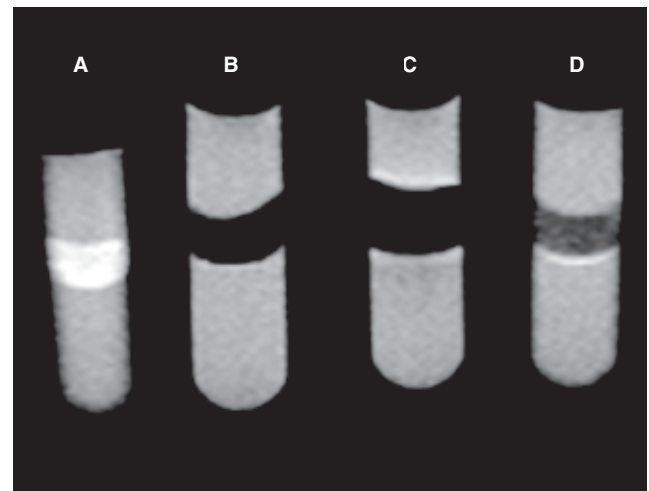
T2-weighted images of USPIO natural killer labeled cells and natural killer cells. A) Unlabelled natural killer cells. B) Ferumoxides Pro-NK-labeled cells. C) Ferumoxides PLL-NK-labeled cells. D) NK-ferumoxides
